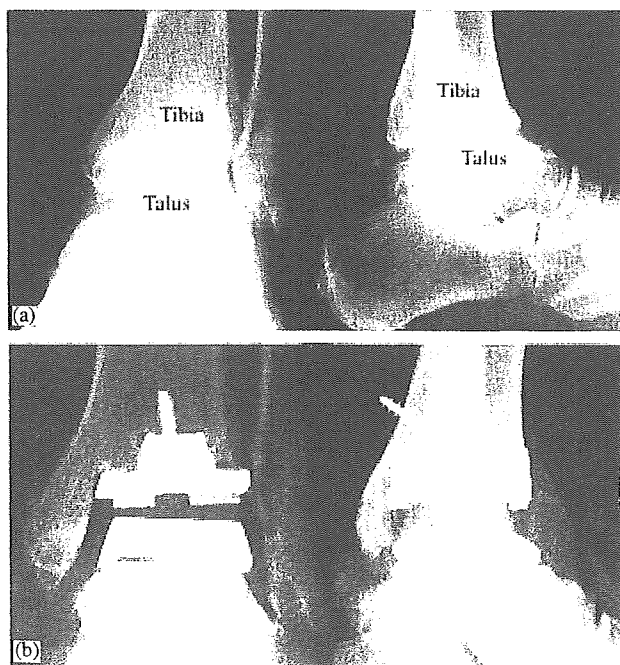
(a) X-ray photograph of ankle joint (case 3) before the operation. Left: anterior–posterior (AP) view. Right: lateral view. The joint space between the tibia and talus is barely recognizable, indicating severe osteoarthritic change. (b) X-ray photograph of case 3 immediately after operation using the tissue engineered ceramic total ankle prosthesis. Left: AP. Right: Lateral view.
